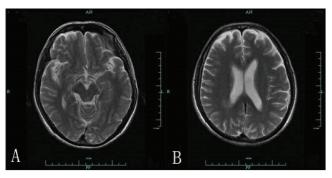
Contrast to Fig. 2 B–C, repeated T2-weighted magnetic resonance imaging (MRI) showing the resolution of the abnormal signal in both occipital and right occipital-parietal lobe.
